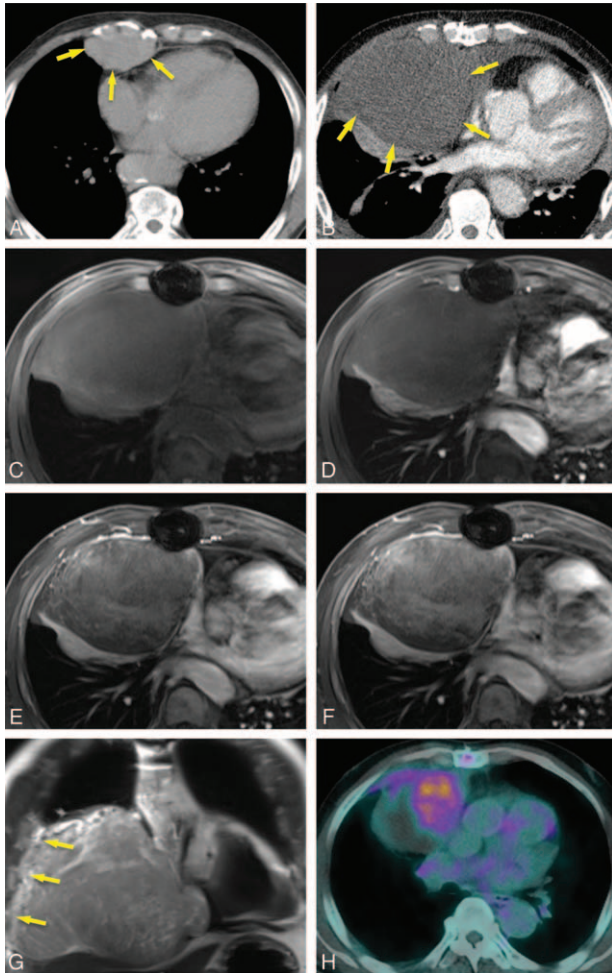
(A) Initial axial image of chest CT (none-enhanced) taken at a local clinic displays a tumor (arrows) in the anterior mediastinum. (B) Axial image of chest CT (contrast-enhanced) taken at admission to our clinic 4 months after initial detection of the mass demonstrates extremely rapid growth of the anterior mediastinal tumor (arrows). The tumor shifts the mediastinum to the opposite side and compresses the right heart. The tumor mainly consists of soft tissue matter with a radiodensity of 27 HU on none-enhanced CT. When iodine-based contrast medium was administered, the tumor was enhanced to only 33 HU, implying hypovascularity. (C) Pre-contrast; (D) Arterial; (E) Portal; (F) Delayed-phase dynamic gadolinium-enhanced chest magnetic resonance imaging (T1-weighted image) reveals a delayed enhancement pattern, indicating a fibrous tumor. (G) Coronal image of gadolinium-enhanced magnetic resonance imaging (T2-weighted image) shows infiltration of the tumor into the chest wall (arrows) and displacement of the right diaphragm to the abdominal cavity by the tumor. (H) 2-deoxy-2-[18F]-fluoro-D-glucose positron emission tomography-CT displays elevated glucose metabolism (maximum standardized uptake value = 5.68). CT = computed tomography, HU = Hounsfield unit.
